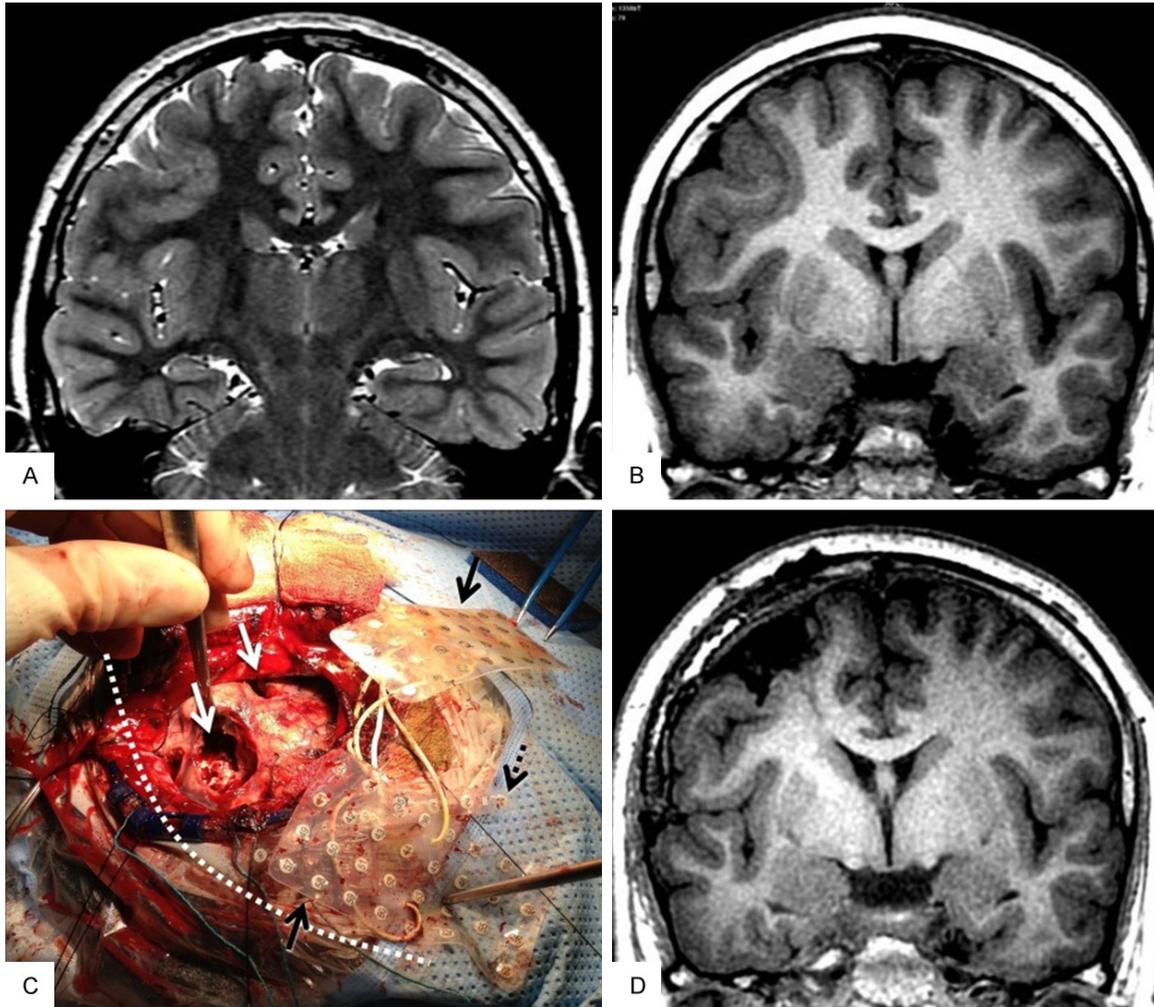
A, B. Preoperative coronal T2-weighted and coronal 3D T1-weighted images show diffuse polymicrogyria involving the right frontal lobe and right perisylvian region. C. Intraoperative photograph showing resection cavities (White arrows) the resection was tailored according to electrocortical recording using two (4×8) grids (solid black arrows) and one (8) strip (dotted black arrow). The midline is indicated by the white dotted line. D. Post-operative coronal 3D T1-weighted image demonstrates partial resection of the right frontal polymicrogyria.
